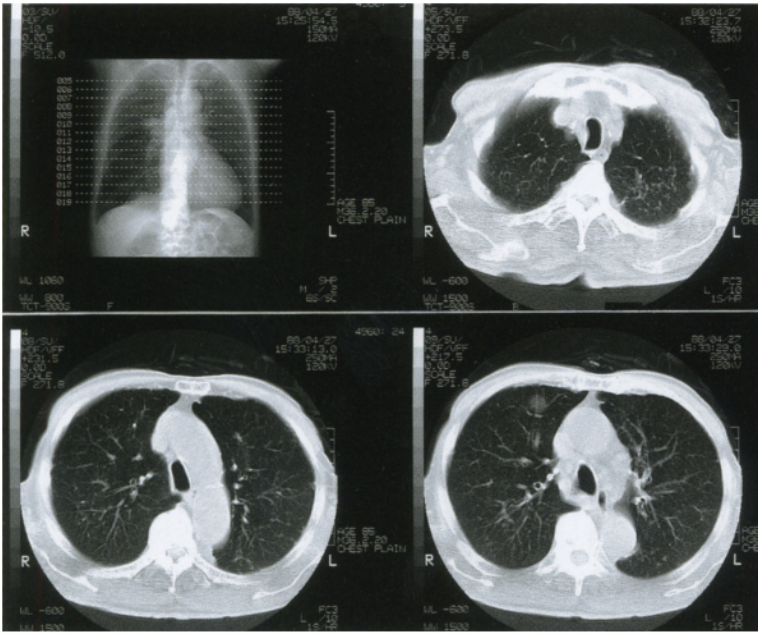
CT scans with 10-mm collimation at upper lung zones show multiple tiny nodules in the posterior portion of both upper lobes
